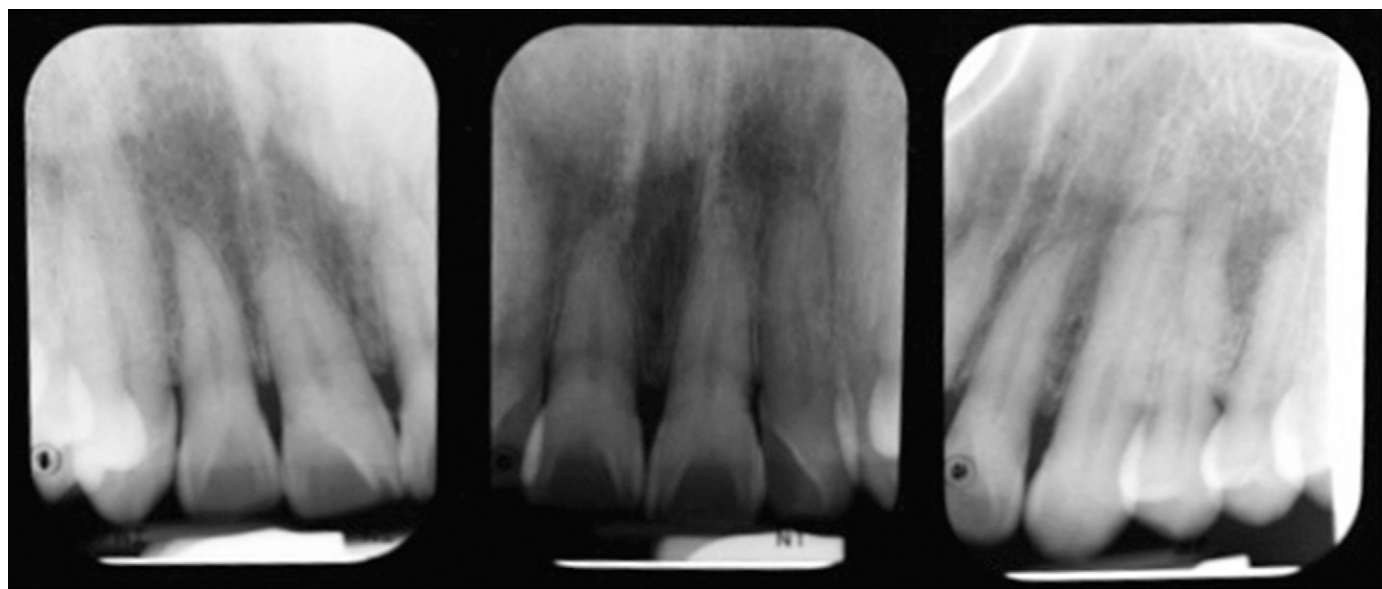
Periapical radiographs of anterior maxilla taken in January 2014 showing a generalized interdental radiolucency.
